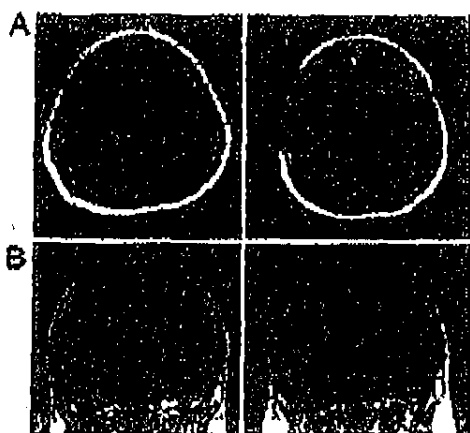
Exemplary T1-weighted, post contrast, MRI scans of recurrent GBM patients before (Left) and after (Right) TTF fields treatment. (A) Complete response after 6 months of treatment. (B) Stable disease (10% reduction in contrast enhancing area) after 9 months of treatment.
